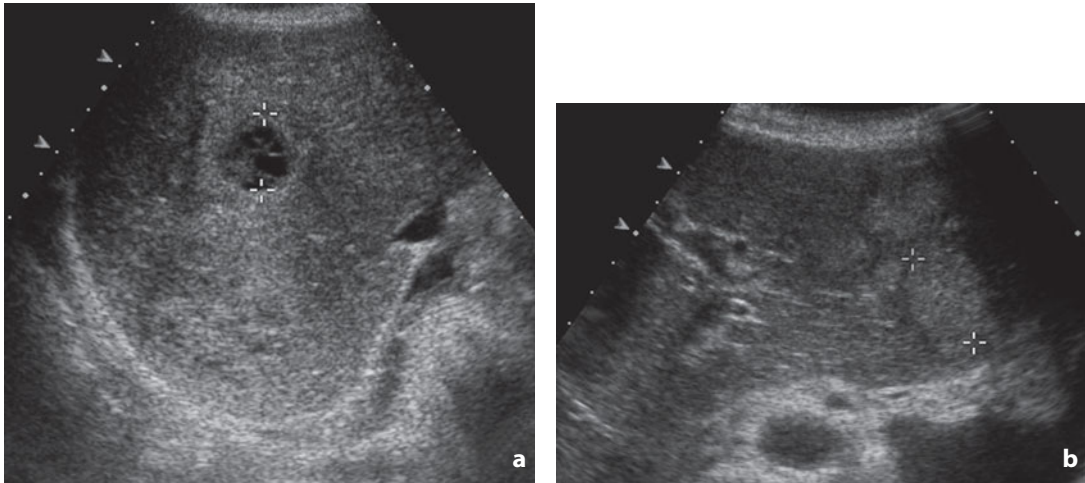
Ultrasonography. Hepatic metastases from ovarian adenocarcinoma. Cystic lesions (a) and hyperechoic solid lesions (b) can be seen coexisting
